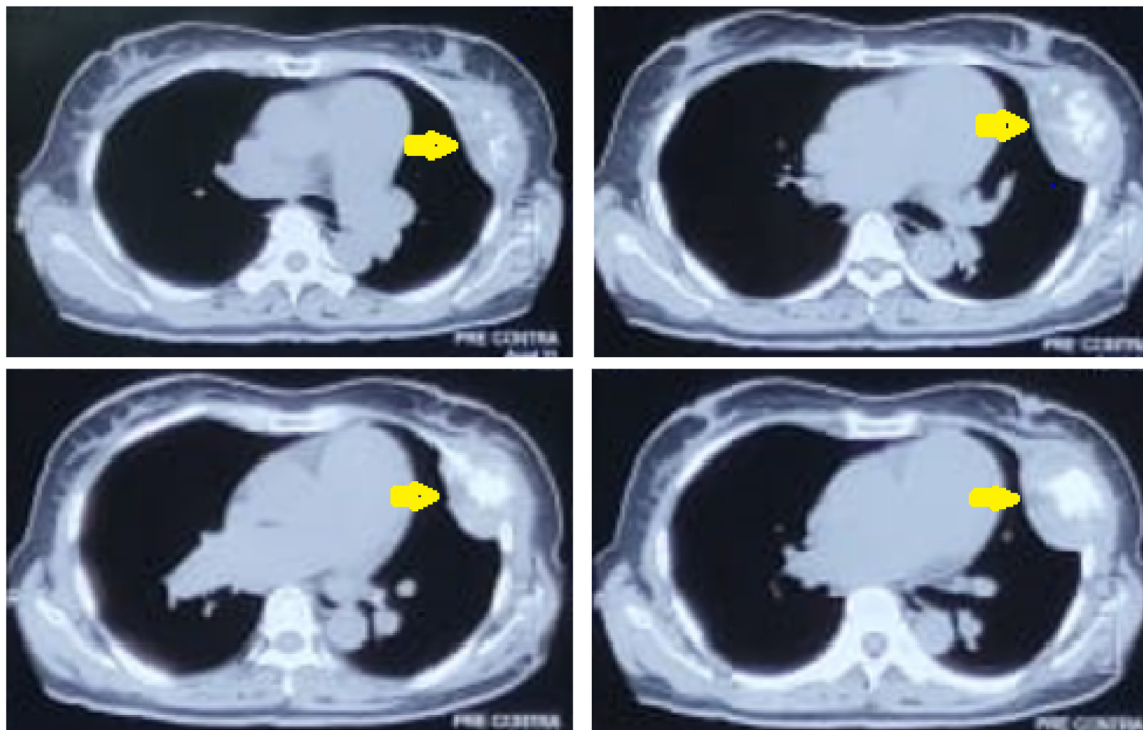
Preoperative CT scan showing bone destruction of the fourth ribs and intralesional calcification.
